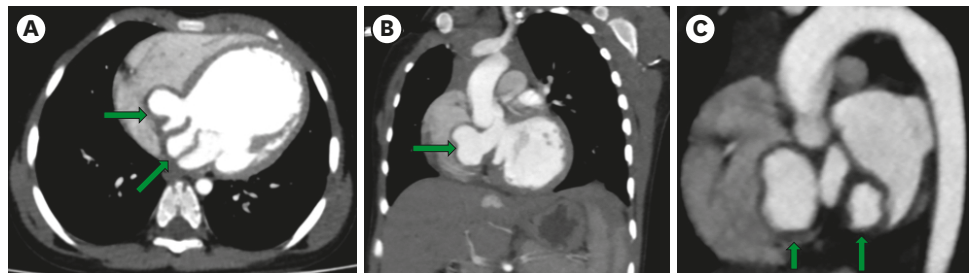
Computed tomographic cardiac angiogram showing multiple sub annular aneurysm in (A) axial view, (B) frontal, and (C) sagittal view (green arrow).
